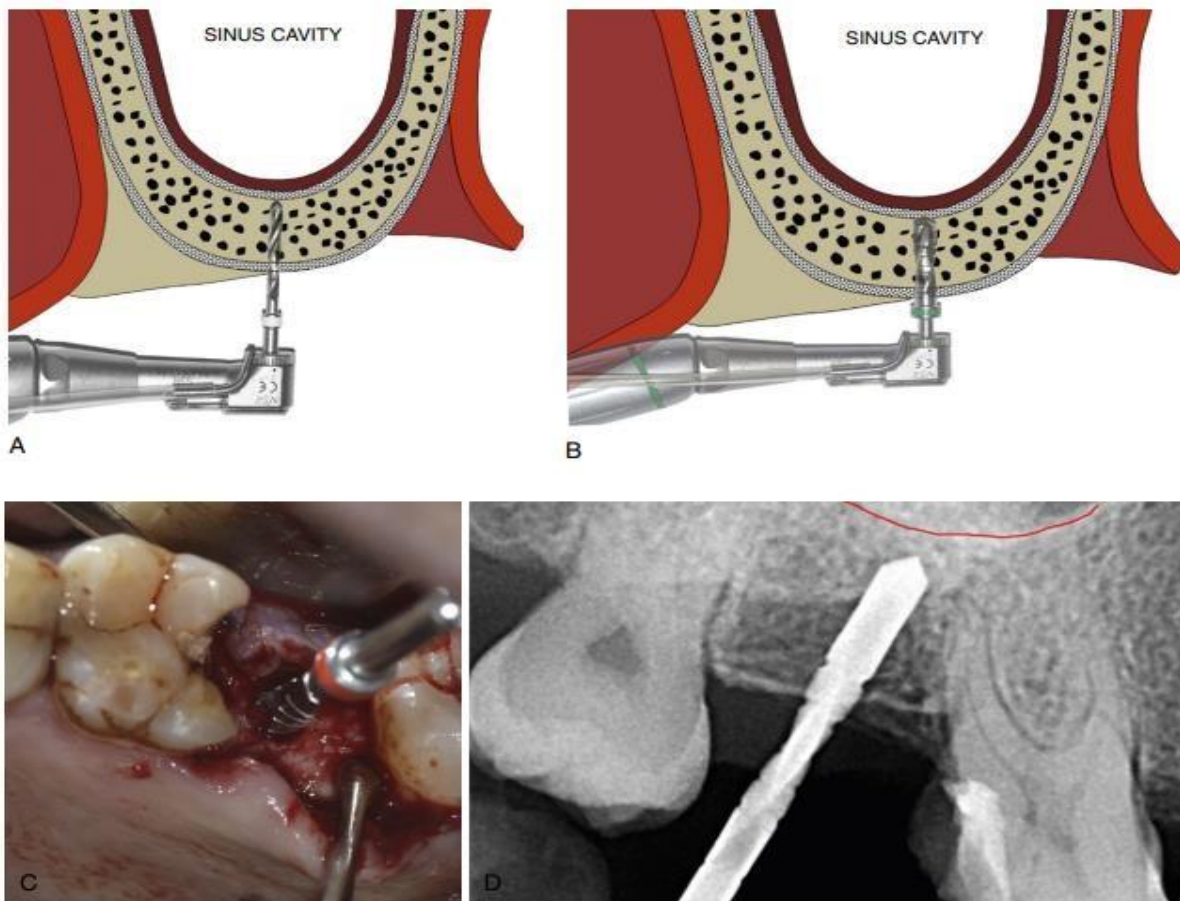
(A–D) Osteotomy for the implant is prepared in the usual fashion using all the drills 2.0 mm short of sinus floor, which can be verified with dental radiographs with the drill in place.
